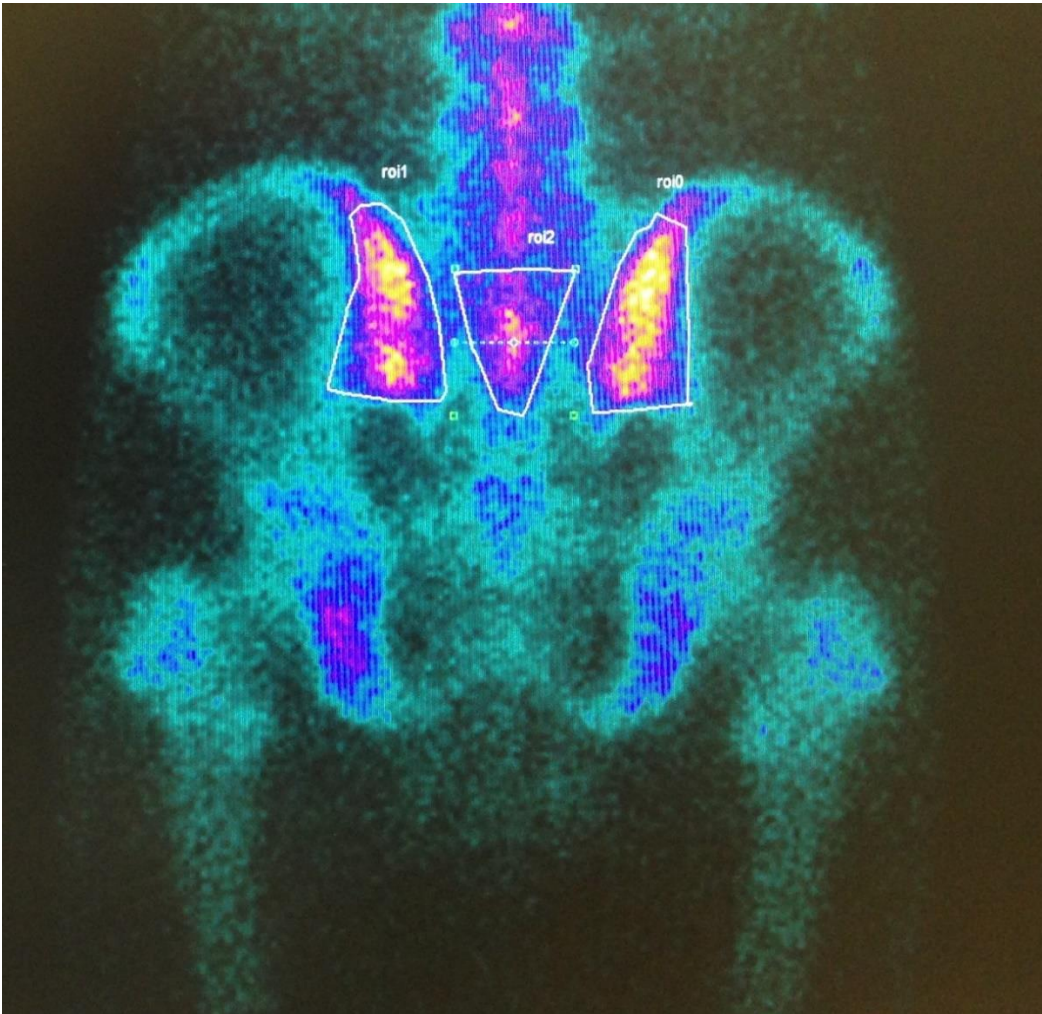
Irregular ROI method. Three ROIs are seen on both sacroiliac joints and sacrum were manually drawn in posterior pelvis image of bone scintigraphy.
